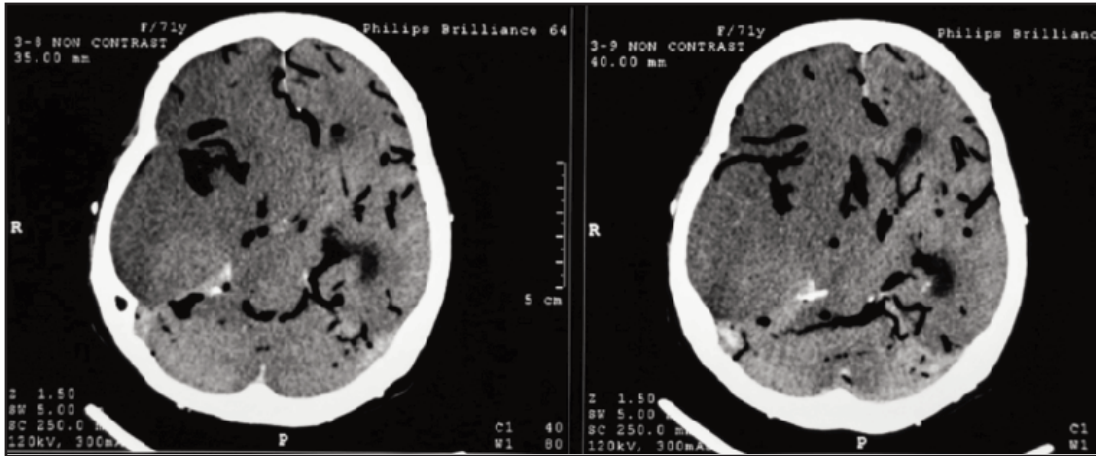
CT brain showing large right middle cerebral artery territory infarct with mass effect and midline shift with generalised cerebral edema predominantly on the right side. Air embolism involving cerebral arteries with pneumoventricles and pneumocephalus were noted.
